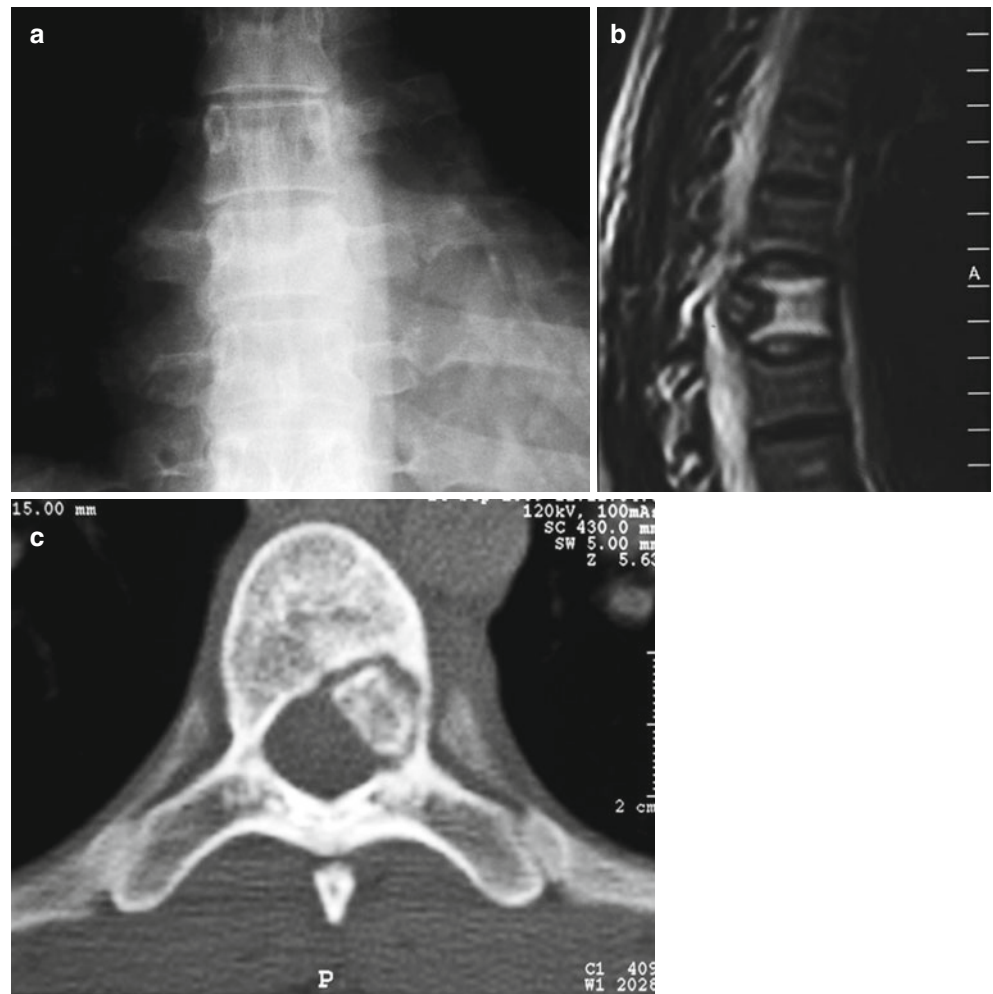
Osteoblastoma characteristically arising in the posterior or dorsal elements of vertebrae as seen in radiograph (a) and CT scan (b)
